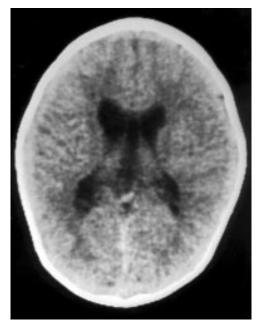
Case 2: MRI of the brain showing a large cyst in the septum pellucidum.
